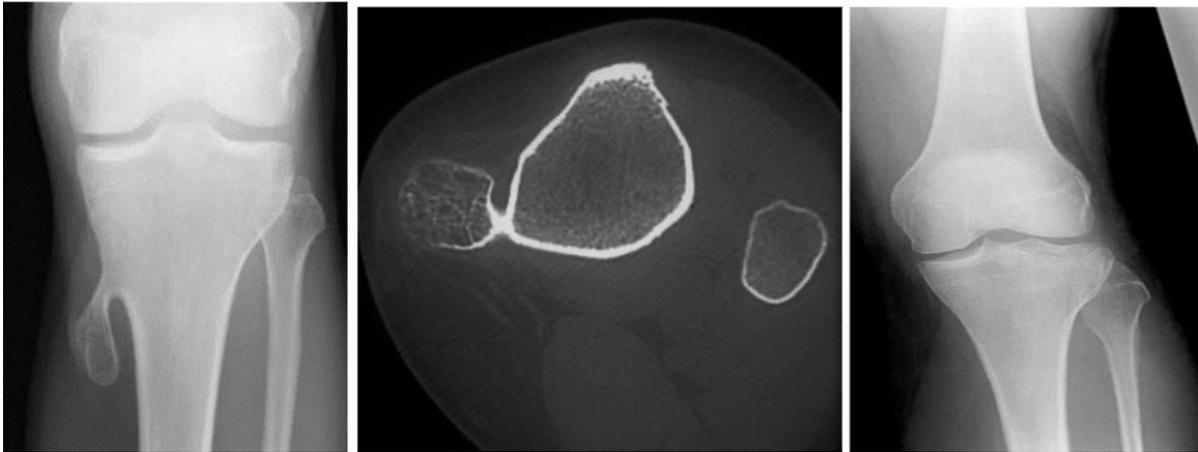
(A) X-RAY of left knee showing pedunculated exostosis from the medial aspect of proximal tibia at metaphysis-diaphysis junction, (B) CT transverse section shows outgrowth from tibia, (c) Post-operative X-RAY after resection of osteochondroma.
